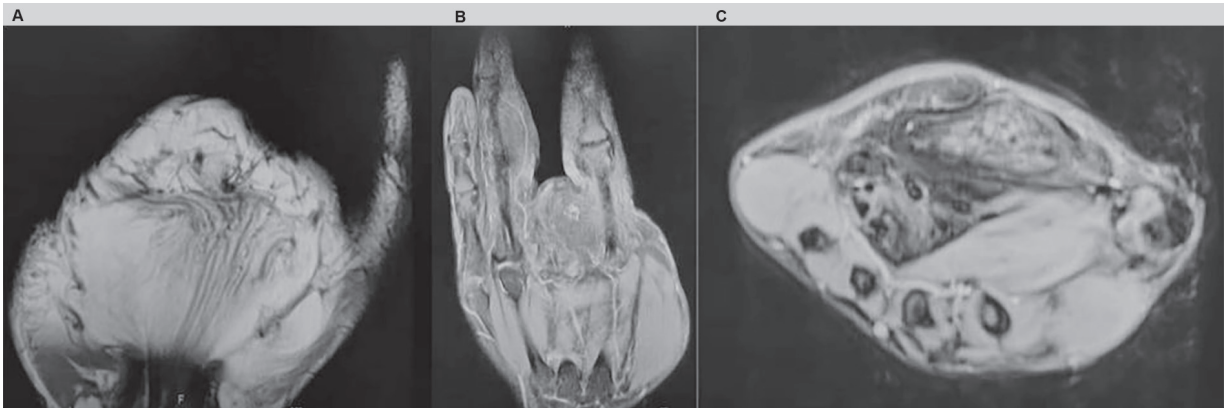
For preoperative MRI, coronal T1 showing serpiginous structures-like changes (A), coronal T2 showing abnormal signal of the ring finger mass occupancy (B), and axial T2 showing coaxial cable-like appearance (C).
